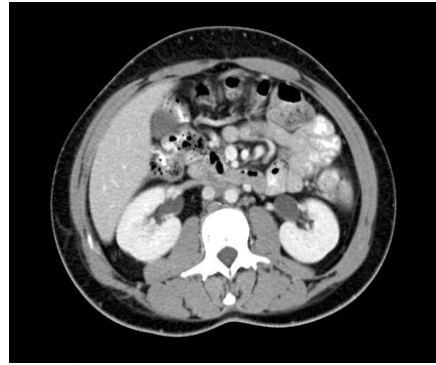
Postchemotherapy CT of the abdomen reveals that the tumor resolved.
